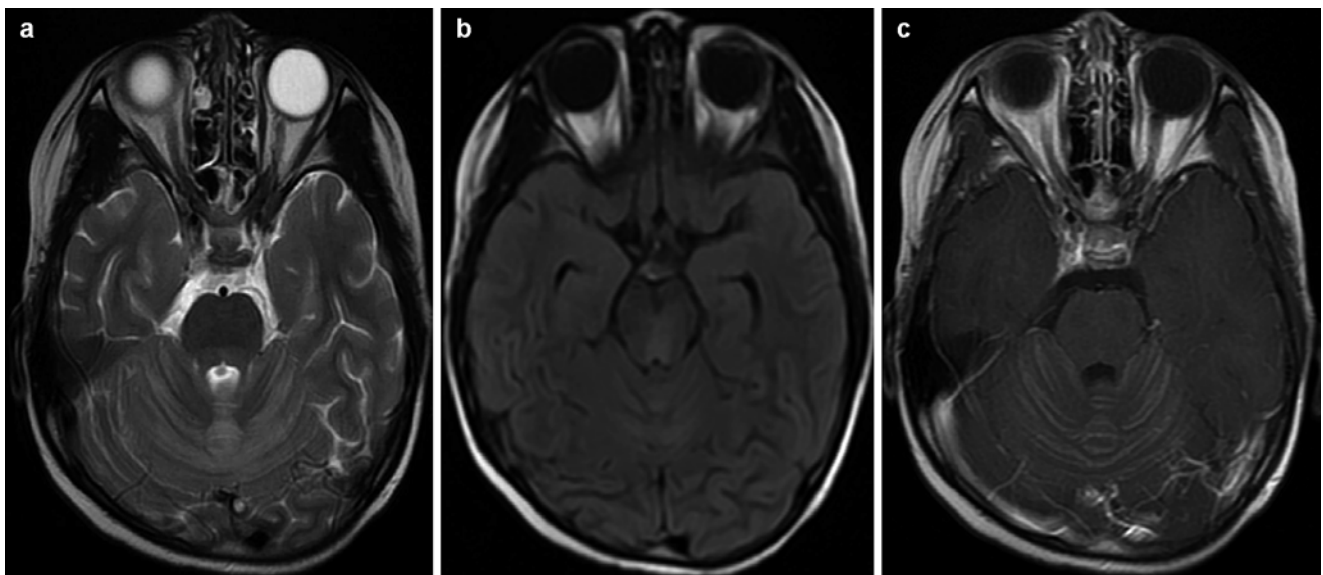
(a–c) A boy aged 7 years with influenza A (H1N1) complicated by meningitis. (a) T2WI showed widened gyri of the cerebellum. (b) FLAIR displayed increased signals at the sulci of cerebellum.
